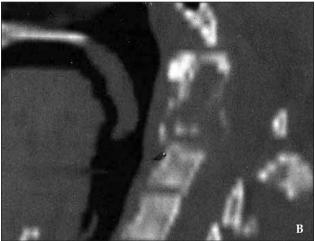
A (transverse), B (sagittal) CT without contrast revealing hypodense-lytic lesion involving the body, lateral masses and the pedicle of the axis.
